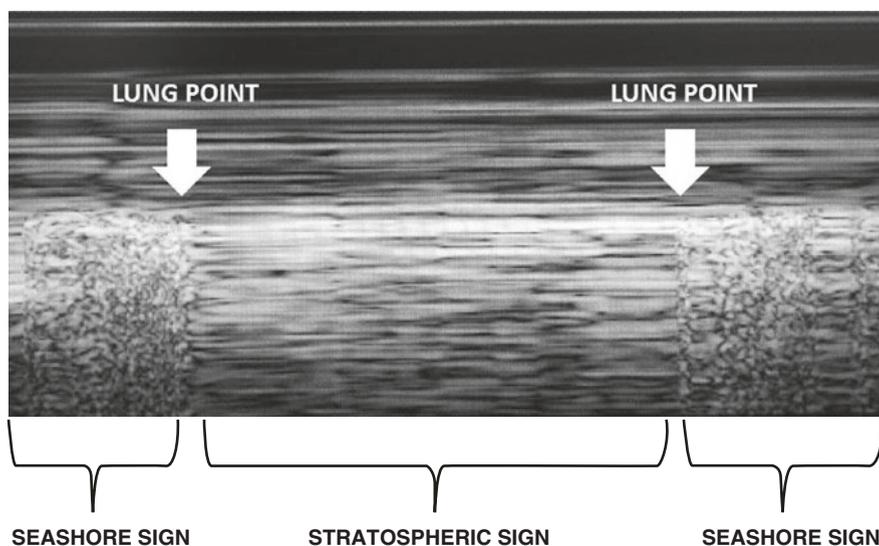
Lung ultrasound, M-mode method
